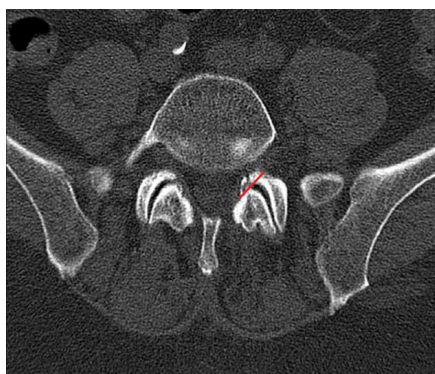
Preoperative CT of patient no. 1 showing the foramininal stenosis making the percutaneous approach impossible, the degree of foraminal stenosis performed is given by the right red line. [Color figure can be viewed at wileyonlinelibrary.com]
